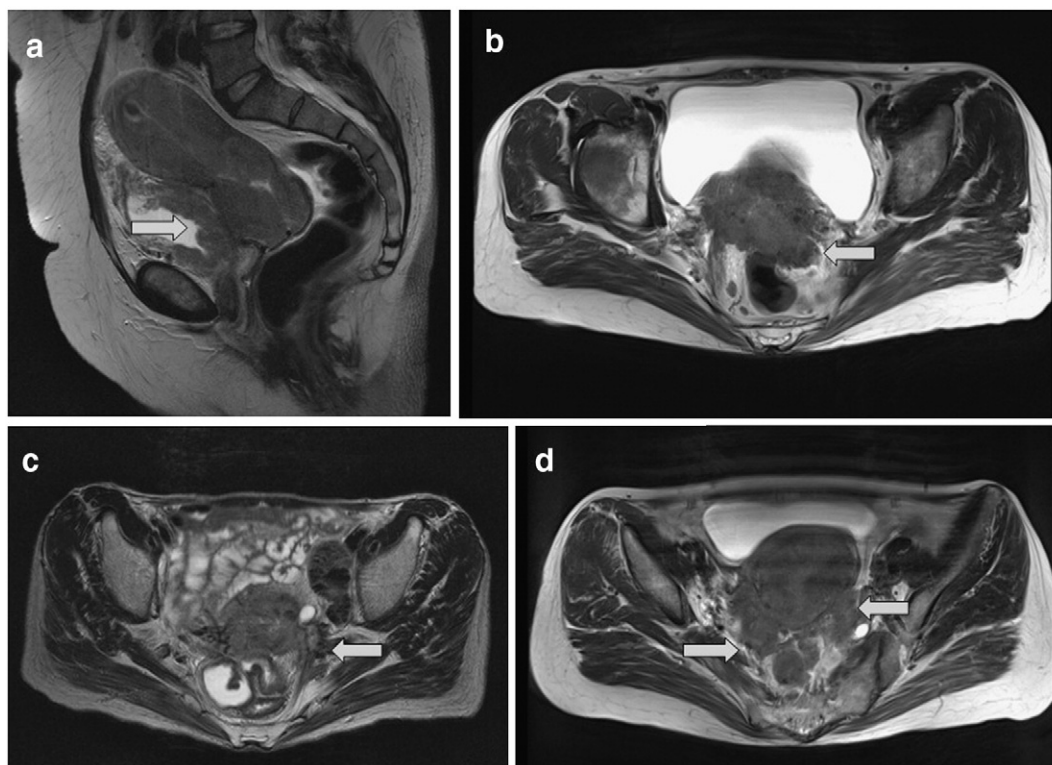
MRI demonstration of advanced cervical cancer transgressing into the bladder (a), mesorectum (b), pelvic wall (c), and peritoneum (d). Arrows indicate sites of extracompartmental local tumor propagation.
